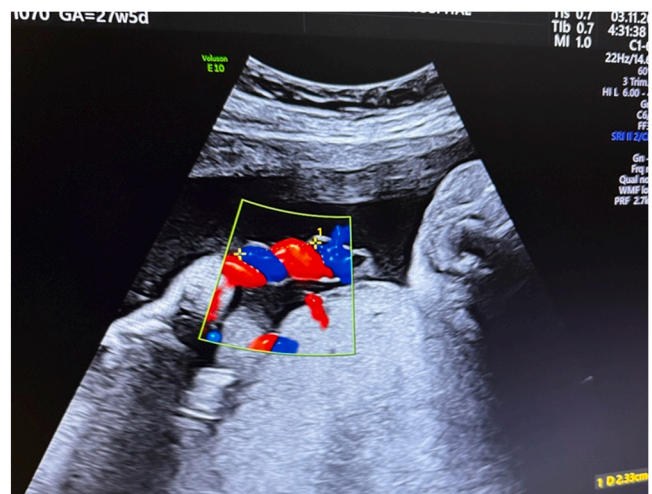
Ultrasound measurement of UCI.
